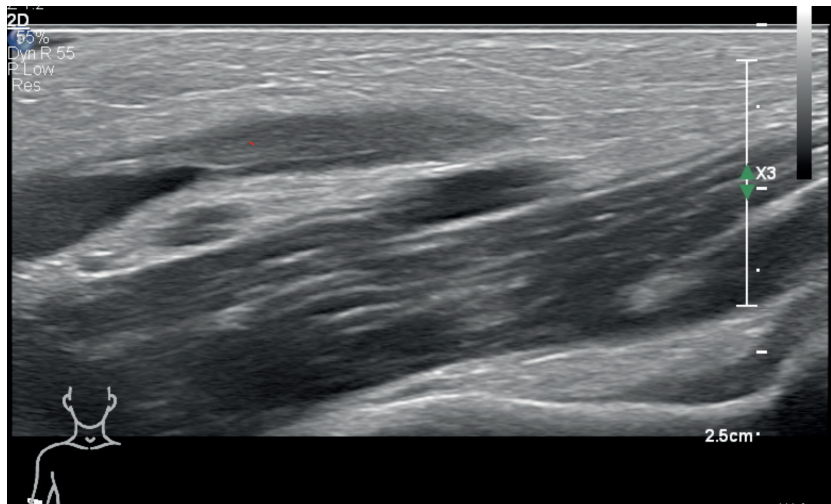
Ultrasonography of basilic vein with a thrombosis.
